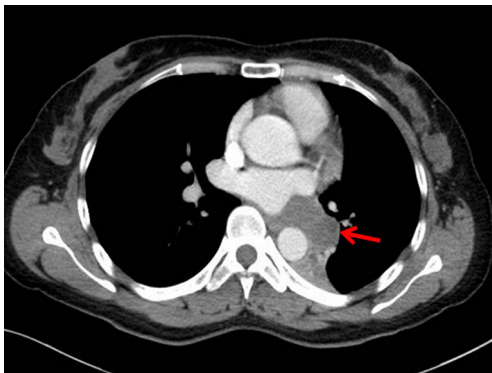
Computed tomography (CT) of chest with contrast revealed a left pulmonary hilar mass (red arrow) with lower lobe atelectasis.
